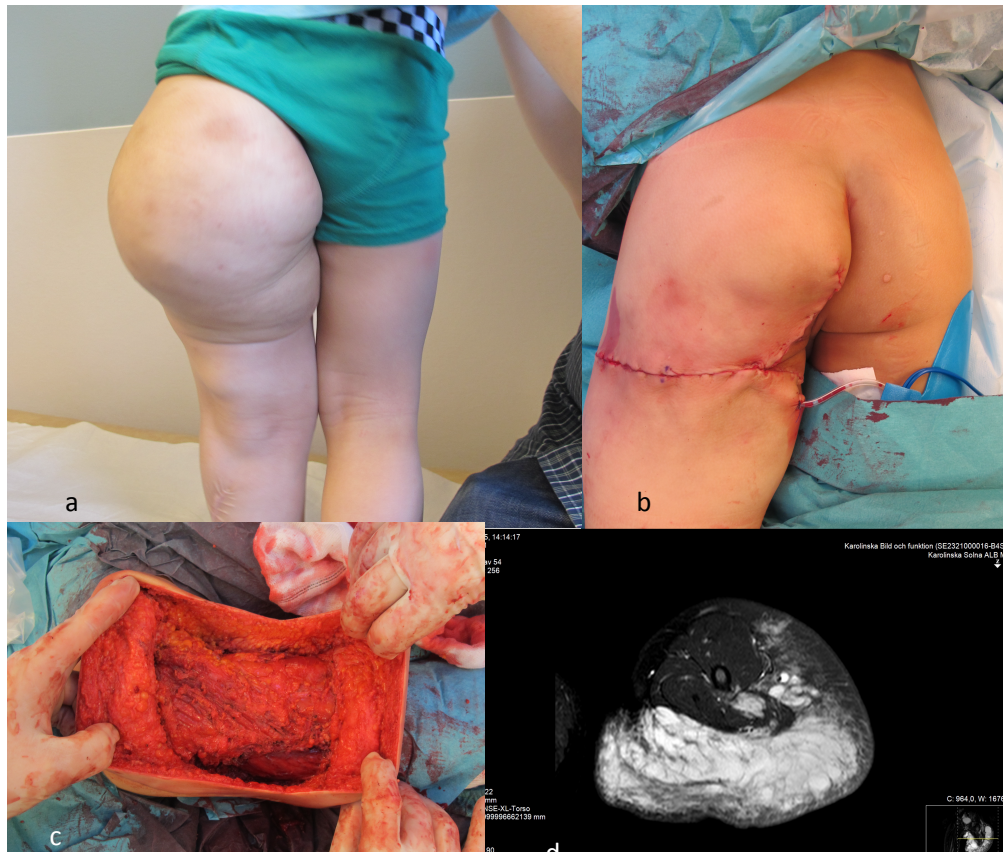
Microcystic LM a Clinical features in the gluteal region, b After surgical debulking, c Intraoperative view after resection of micocystic LM, d MRI T2 weighted image showing microcystic LM.
